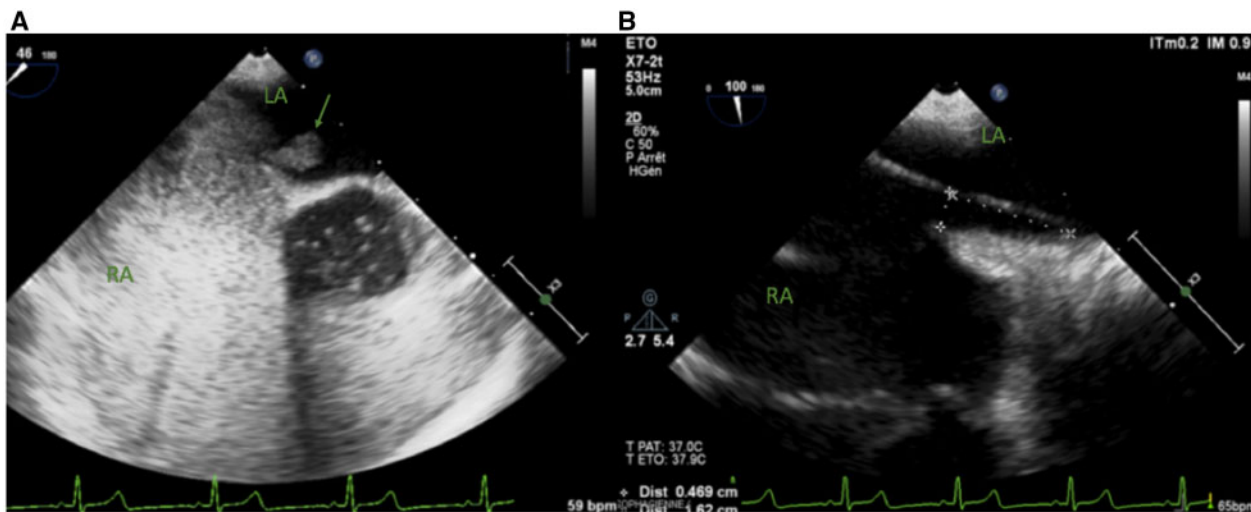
Pre-procedural transoesophageal echocardiography images showing: (A) large right to left shunt (>30 bubbles); (B) length of patent foramen ovale tunnel (16 mm). Green arrow, large shunt; LA, left atrium; RA, right atrium.
